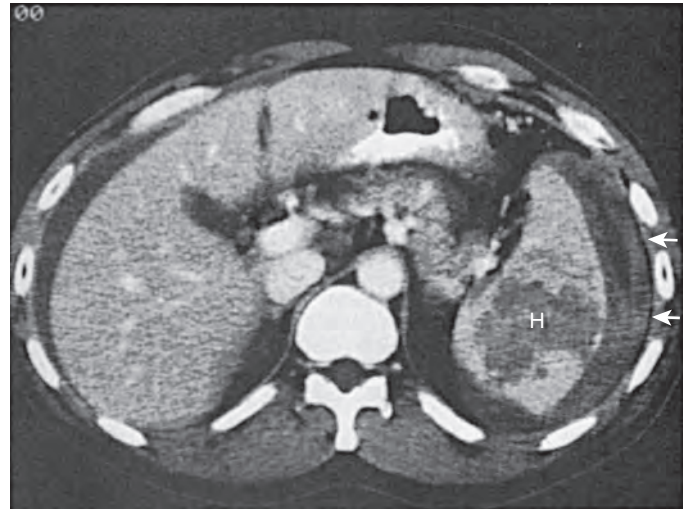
Delayed splenic rupture. Enhanced CT scan of a 17-year-old patient who presented with worsening abdominal and left shoulder pain 1 week after being kicked in the abdomen. A low-attenuation splenic hematoma (H) and associated perisplenic fluid and hemorrhage (arrows) are identified. Splenectomy was required.
